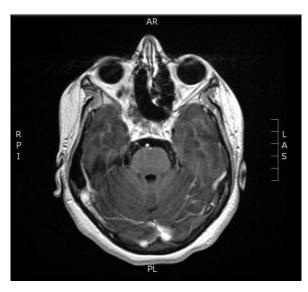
MRI 1 month post-operative showing resolution of the disease.
